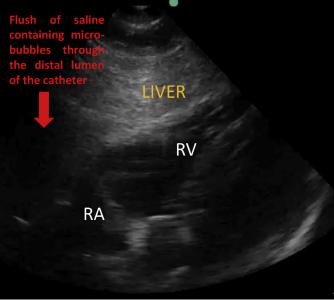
(a) Bedside chest radiograph showing the inadequate positioning of the hemodialysis catheter in the ipsilateral right internal jugular vein after catheter insertion in the right subclavian vein (black arrow). (b) Ultrasound subxiphoid view showing right atrium (RA) and ventricle (RV) before the administration of microbubbles through the distal lumen of the catheter. (c) Ultrasound subxiphoid view showing the absence of microbubbles in RA and RV 4 seconds after their flush through the distal lumen of the catheter. Dynamic views can be visualized in Figure 5.
